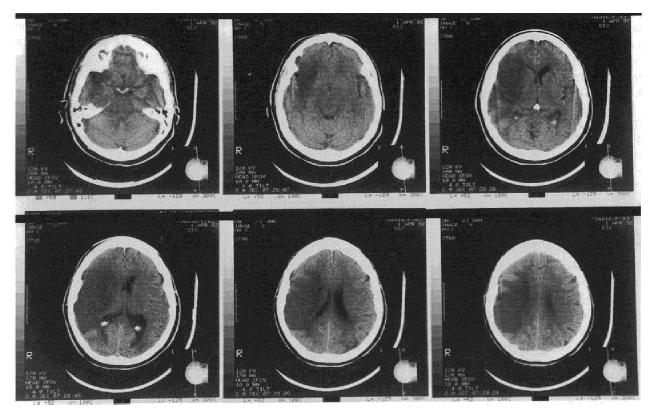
The patient's CT scan 3 days after onset showed a large right middle cerebral artery infarction involving the frontal, temporal, and parietal lobes.
